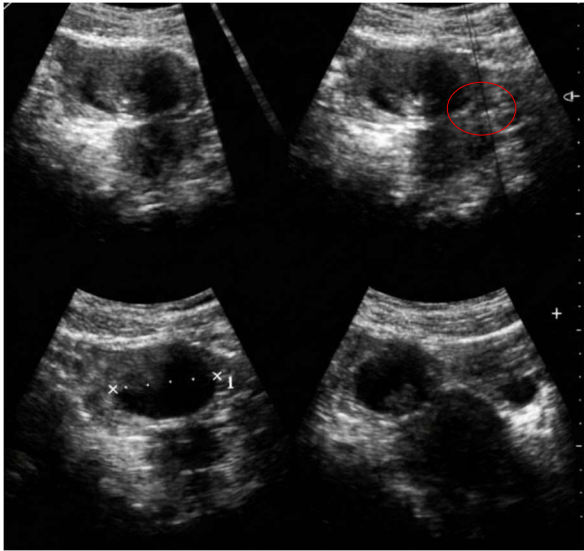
Pelvic ultrasound showing an annexial ectopic pregnancy of 09 weeks 03 days (red circle).
